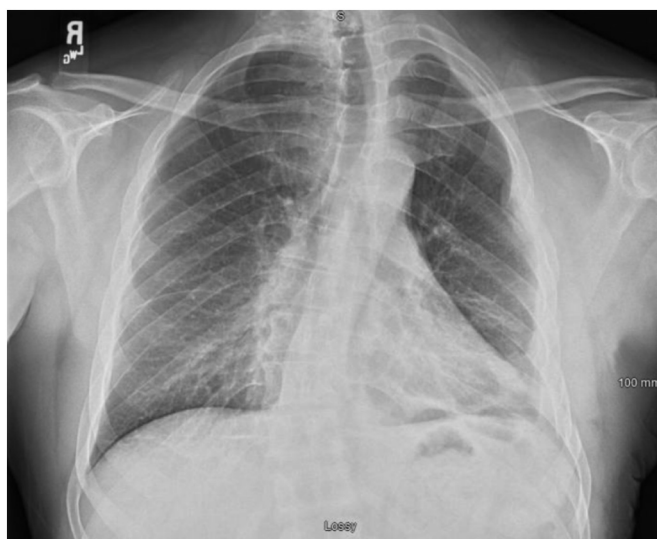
Three month follow up chest radiograph.
